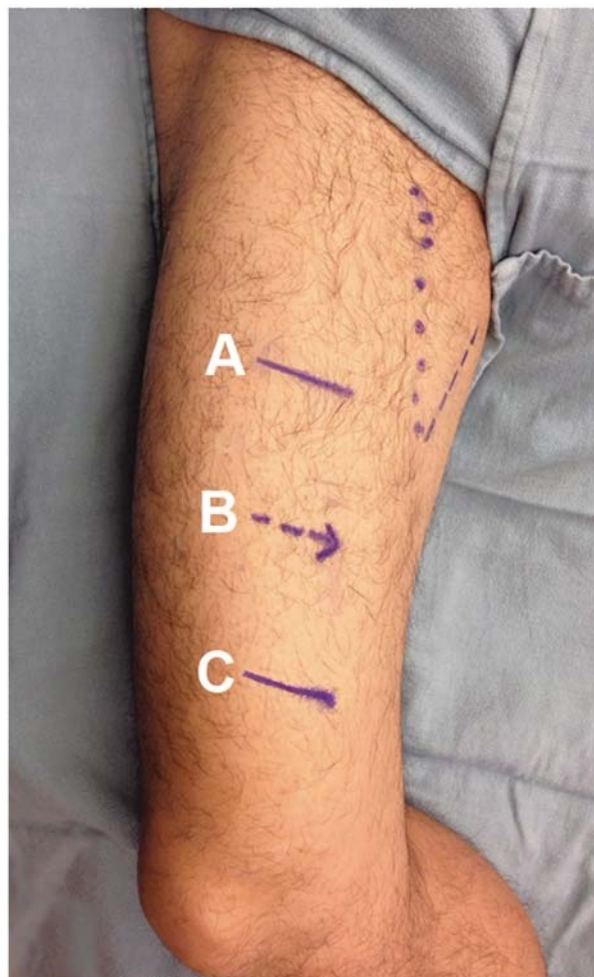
Surface anatomy of the right thigh as delineated by ultrasound examination. The medial borders of the sartorius (dotted line) and adductor longus muscles (broken line) have been mapped distally to their intersection at the apex of the femoral triangle. A corresponds to a sonographic plane at the apex of the femoral triangle. B corresponds to a suggested ideal local anesthetic injection site in the mid-adductor canal. C corresponds to the distal end of the adductor canal at the level of the adductor hiatus.
